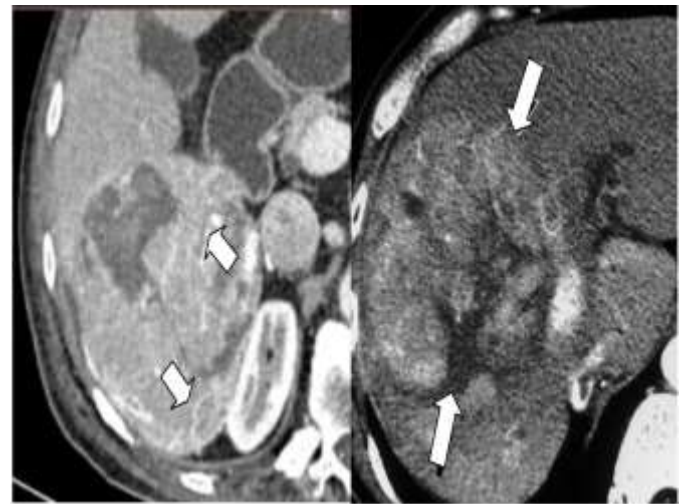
Abnormal internal vessels or variegated pattern in two different patients depicted on transverse arterial phase CT scans. HCC with visible internal vessels (arrow) that are irregular in contour. In the second patient HCC (arrows) with randomly distributed hyper- and hypoattenuating regions.
